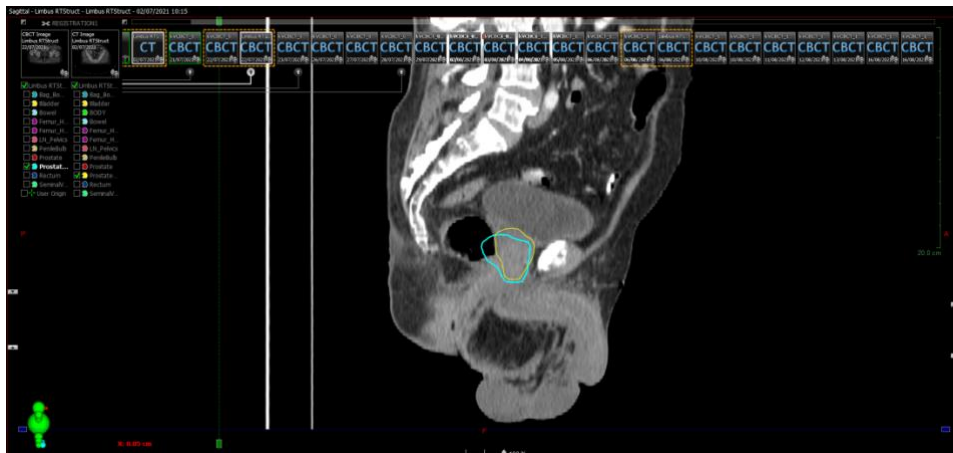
Sagittal slice of planning CT. Note distended rectum with resultant anterior displacement of prostate. Prostate contoured on planning CT in yellow. Prostate contoured on CBCT in turquoise.
